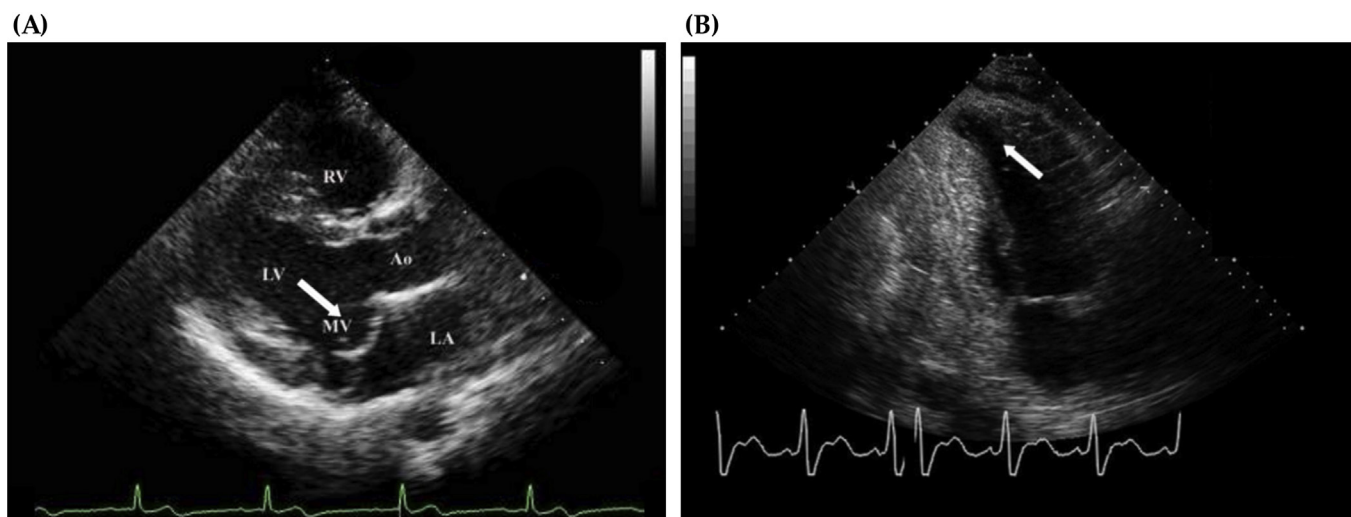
Examples of cardiac anatomic and functional abnormalities such as mitral valve prolapse (A; arrow; long axis parasternal view) and an LV aneurysm (B; arrow). Adapted from Janiec et al. [125] and Kasirye et al. [126], respectively.
